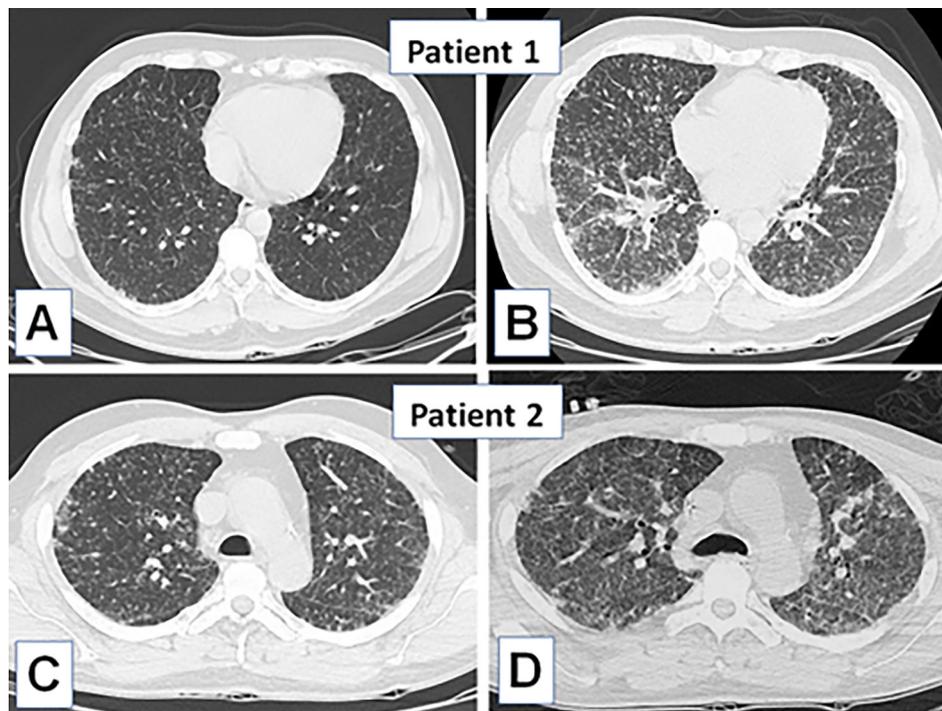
Chest CT images showing the evolution of the pulmonary infectious process in two critically ill patients: A and B) Patient 1 with images of 4 days of evolution; C and D) Patient 2 with images of 14 days of evolution. The images show a granulomatous involvement in the form of micronodules, initially sparse, progressing to a disseminated form in the lungs (miliary opacities).
